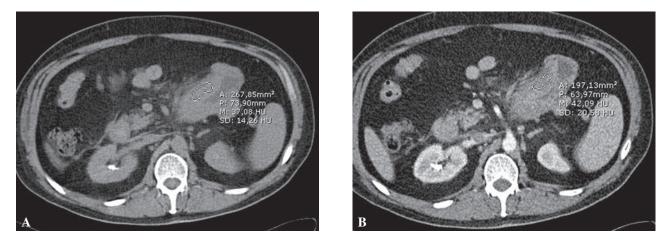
A 57 year-old male who used an oral anticoagulant after placement of a prosthetic valve (patient #2 of Table 1) (A) Axial pre- and (B) post-contrast CT images ; and (C) a coronally reformatted CT image, reveal a thickened jejunal wall (double white arrows) (pre-contrast value ; +37 HU, post-contrast value ; +47 HU). The aterix shows a hemoperitoneum.
